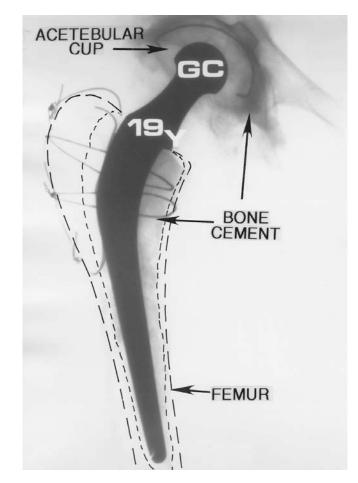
(a) Radiograph of bone cement fixed Charnley hip joint (monolithic femoral and acetabular component, 15-year follow-up).
